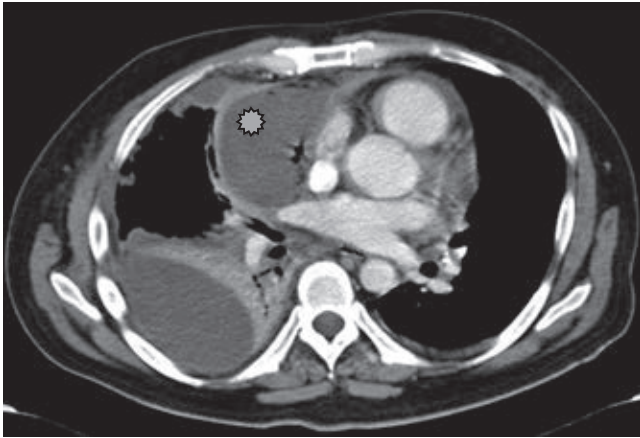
Contrast-enhanced computed tomography, axial plane, demonstrates liquid collection in paracardiac situation, with some air densities inside, minimal enhancement, with displacement of adjacent structures (asterisk).
